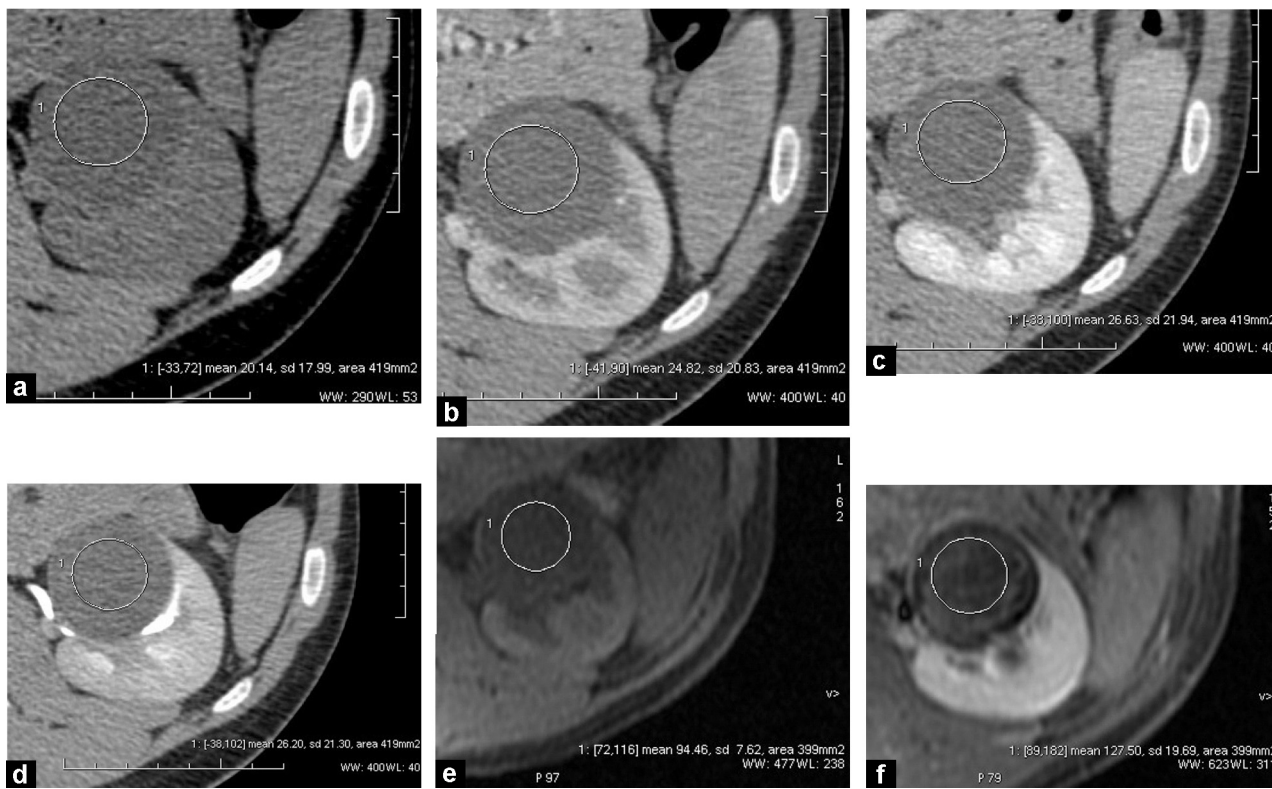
Papillary carcinoma without enhancement (7 HU difference between the tubular phase and pre-enhancement image), exhibiting significant contrast enhancement on MRI (36% enhancement); a: unenhanced CT; b: CT: arterial phase; c: CT: tubular phase; d: CT: delayed phase; e: MRI: T1 weighted image without enhancement; f: MRI: T1 weighted image in the delayed phase.
